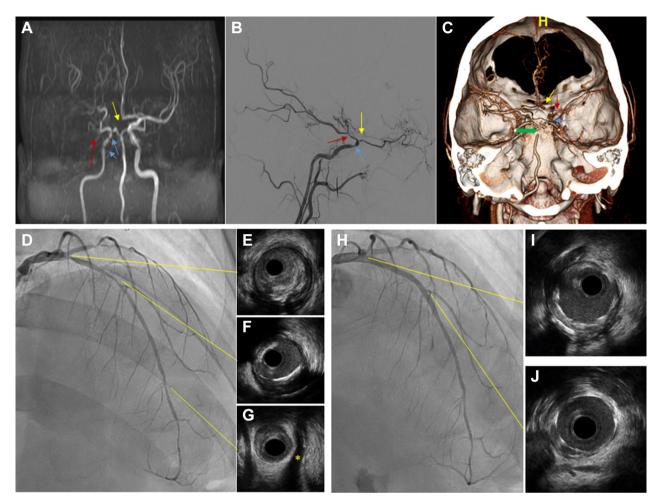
Severe steno-occlusive disease of the distal right internal carotid artery (blue arrows) with diminutive anterior cerebral artery (yellow arrow) and M1 segment of the middle cerebral artery (red arrow) with supply of the distal segments via collaterals and basilar artery occlusion (green arrow); as seen in time-of-flight magnetic resonance angiography (A), lateral internal view cerebral angiogram (B) and 3D volume rendering (C). Coronary angiogram showing severe disease in the ostium, mid, and distal LAD (D); co-registered IVUS images of the respective lesion locations (yellow asterisk depicts myocardial bridge) (E-G). Coronary angiogram after percutaneous coronary intervention (H) and respective IVUS images in the ostial (I) and mid (J) LAD showing optimal stent expansion and apposition. IVUS, intravascular ultrasound; LAD, left anterior descending artery.
